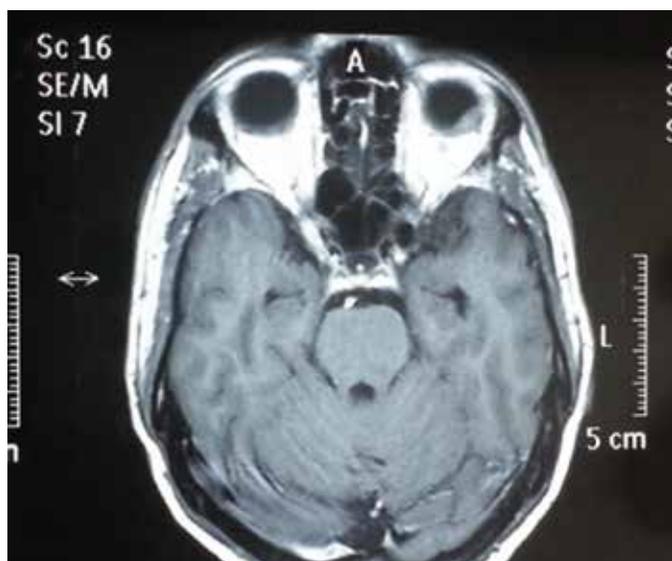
MRI brain and orbit (T1)
